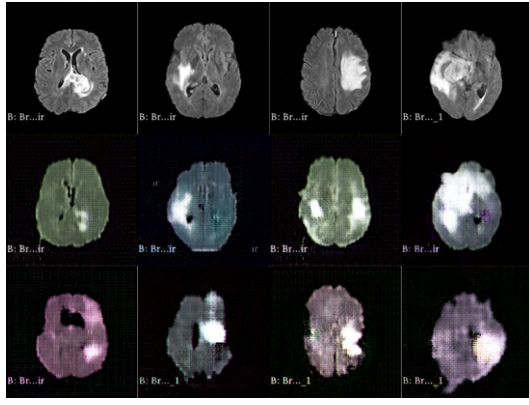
Comparison between real MRI images (upper row), success cases (middle row), and failure cases (lower row)
